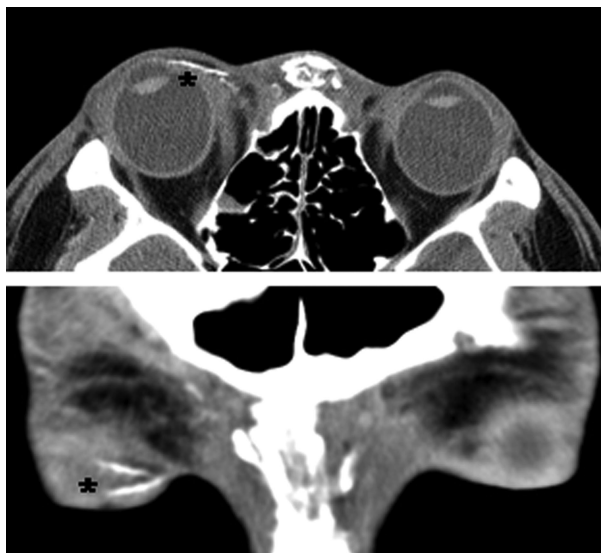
Orbital CT scan with axial and coronal views demonstrates linear deposits of similar density to bone in the right medial orbit and eyelid, suggestive of multiple emboli along the conjunctival vessels (asterisks).
